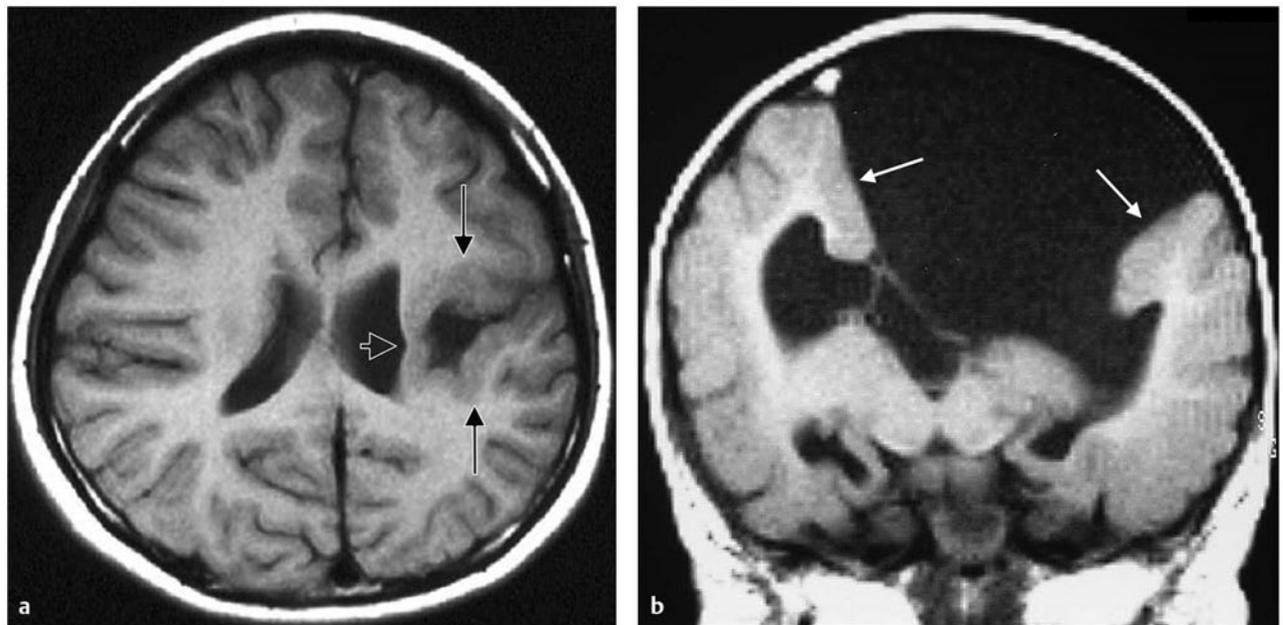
Schizencephaly. (a) Axial T1-weighted magnetic resonance image shows a left unilateral closed-lip schizencephaly. The walls of the transmantle cleft are apposed and lined by gray matter (arrows). Note the deformity in the lateral ventricle, where the ependyma is continuous with the cleft (open arrow). (b) Coronal T1-weighted magnetic resonance image of another child shows gray matter (arrows) lining a left unilateral open-lip cleft.
